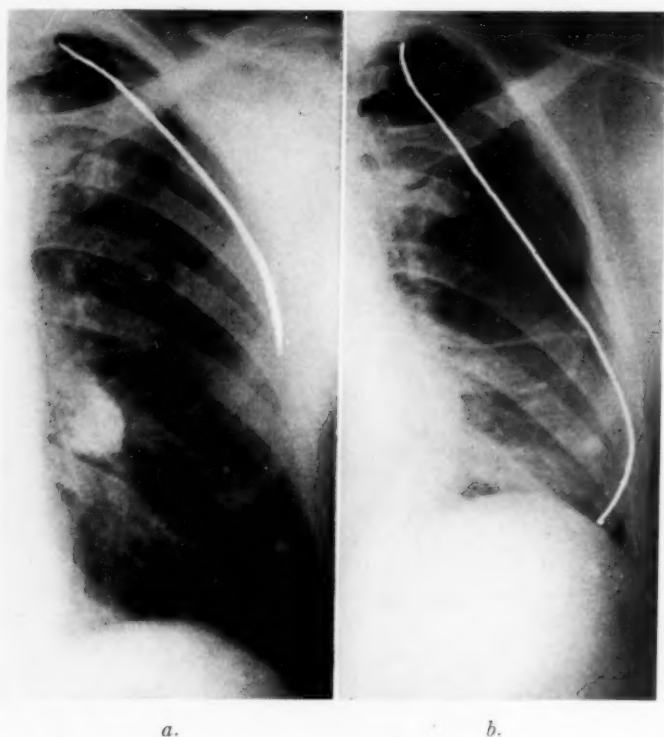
(a) deepest inspiration; (b) deepest expiration. These roentgenograms show how much more easily a small pneumothorax is visualized in expiration than in inspiration.
